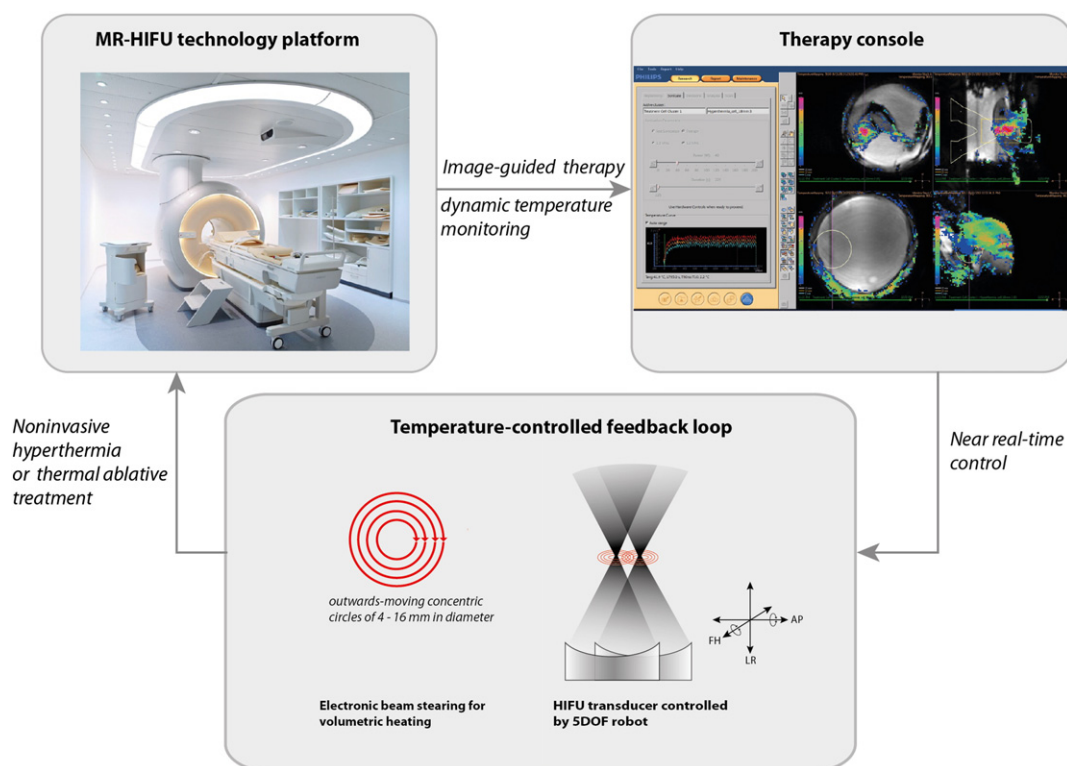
MR-HIFU system (Sonalleve®, Philips Healthcare) designed for the thermal ablation treatment of uterine fibroids. A phased array ultrasound transducer containing 256 separate elements is embedded in the table top of the MRI scanner. The phased array design allows prolonged volumetric heating of larger volumes of tissue to a homogeneous temperature using MR thermometry as feedback [81]. The above example shows 30 min of *in vivo* hyperthermia treatment in rabbit thigh muscle. Image courtesy of Steffie Peters.
